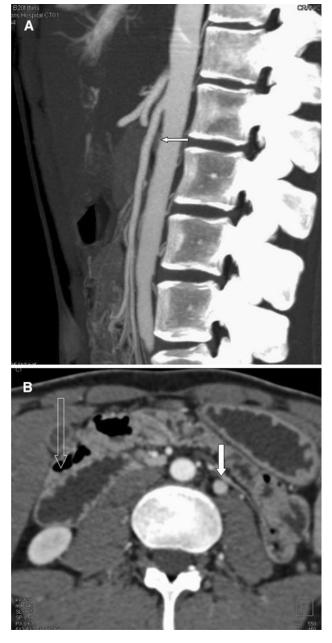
A 20-year-old female with nausea, vomiting, and weight loss, as well as post-prandial abdominal pain since the age of 14. She had lost roughly 30 pounds over the last few months. Sagittal CT MIP image (A) demonstrates narrowing of the aortomesenteric angle and distance, with compression of the duodenum (*arrow*). Axial CT image (B) demonstrates a dilated duodenum (*open arrow*) proximal to where it crosses beneath the SMA. The left gonadal vein is dilated (*closed arrow*), an ancillary finding of SMA syndrome.
